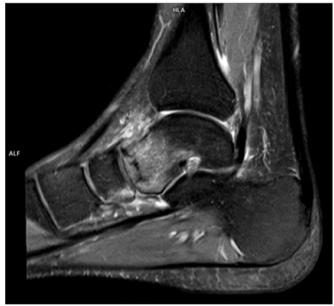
MR examination of the right ankle joint in the sagittal plane; T2-weighted fat-sat image – fatigue fracture in the talus with extensive swelling.
